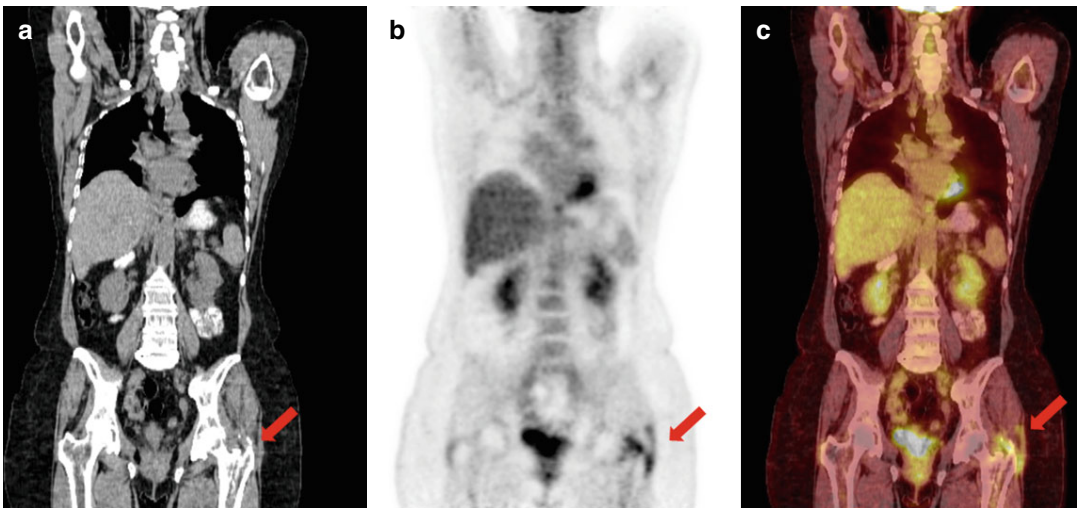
Coronal CT (a), PET (b), and fused PET/CT (c) images show the hypermetabolic lesion of the intertrochanteric region of the left proximal femur with concomitant infiltration of the adjacent muscles/soft tissues of the hip (red arrow)
